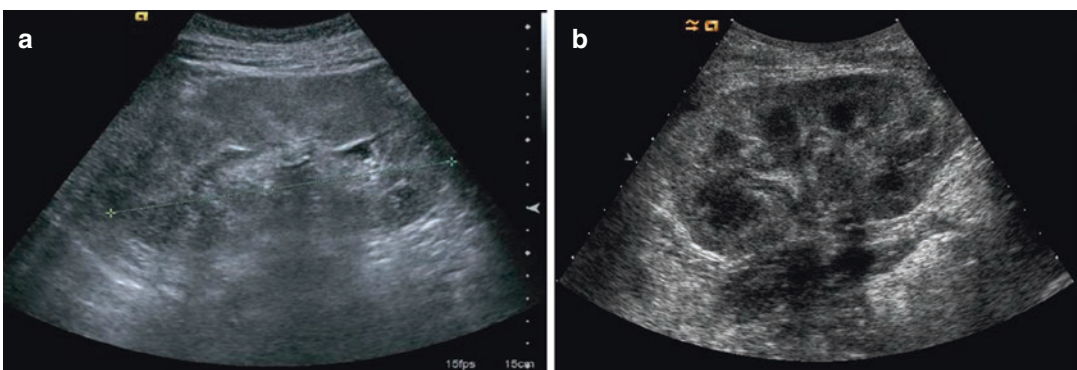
AKI arising from acute glomerulonephritis or systemic vasculitis involving the kidneys. Renal morphology on ultrasound sometimes shows (a) a specific globular pattern with central sinus compression and increased
